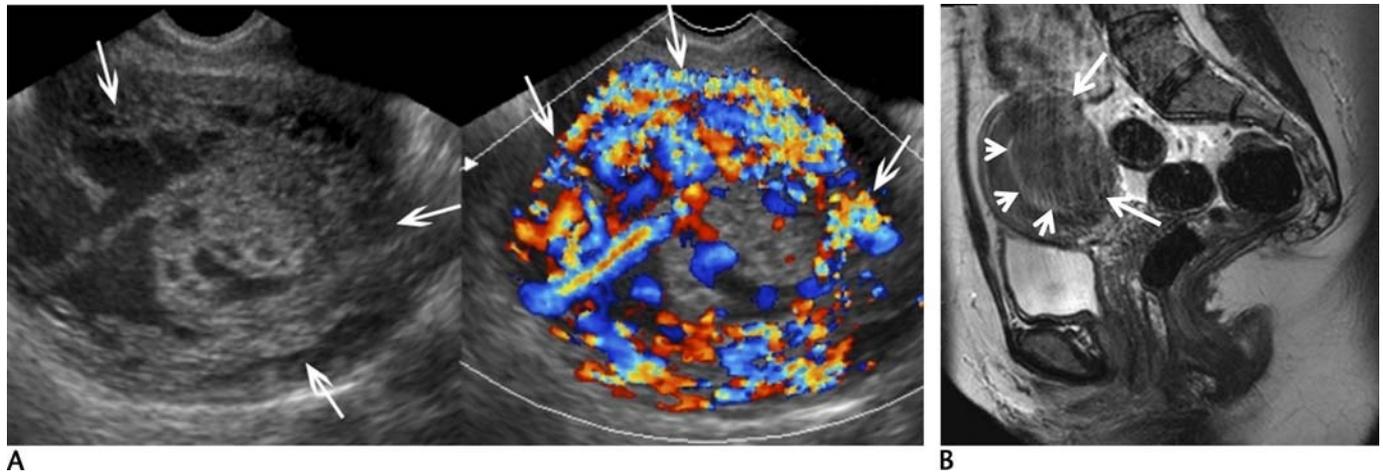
Invasive molar pregnancy. A 35-year-old woman with a history of complete molar pregnancy, who was treated with dilatation and curettage, now presents with persistently elevated HCG levels. A, Gray scale and color Doppler transverse ultrasound images of the uterus at the same level show a distended endometrial cavity filled with heterogeneous vascular soft tissue and loss of distinction between endometrium and myometrium (arrows). Massively enlarged multicystic ovaries (theca-lutein cysts) were also seen on the ultrasound examination (not shown). B, Sagittal T2-weighted magnetic resonance image in a different patient shows a low signal intensity mass projecting into the endometrial canal (short arrows) with loss of the posterior junctional zone (long arrows). The mass proved to be an invasive mole.
